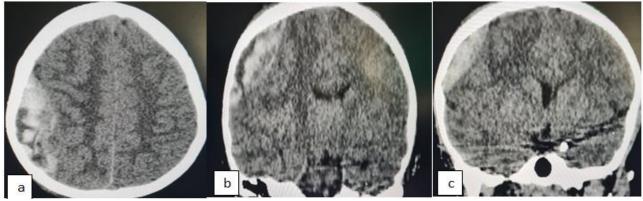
Spontaneous contrast brain CT a: axial section, b, c: coronal section
